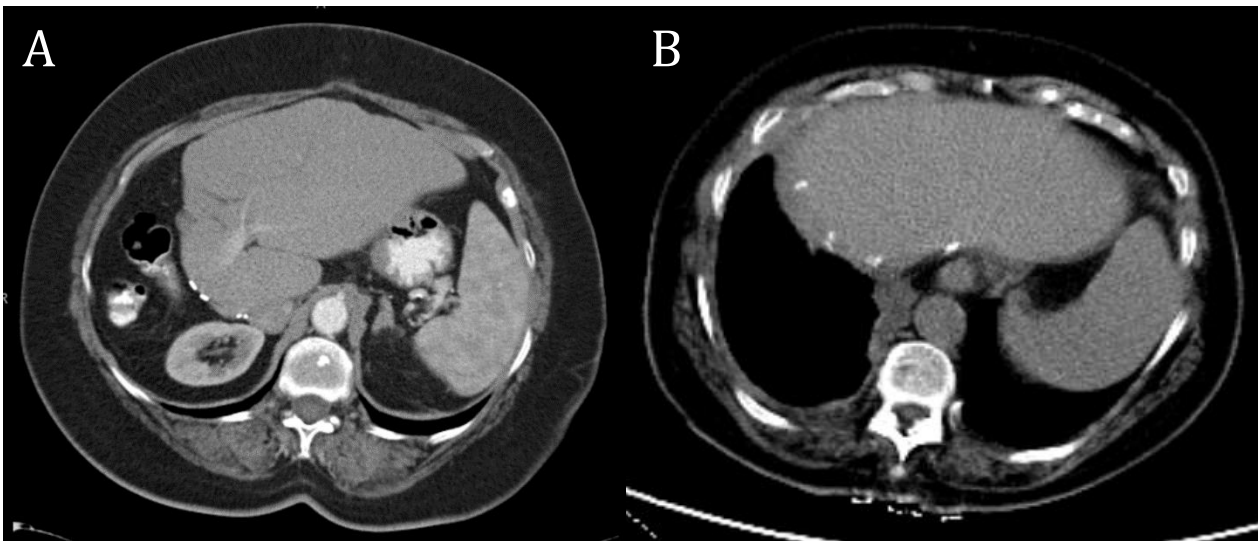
Computed tomography (CT) of the abdomen on presentation (A) and with malignancy recurrence (B), year 2006 and 2016 respectively.
